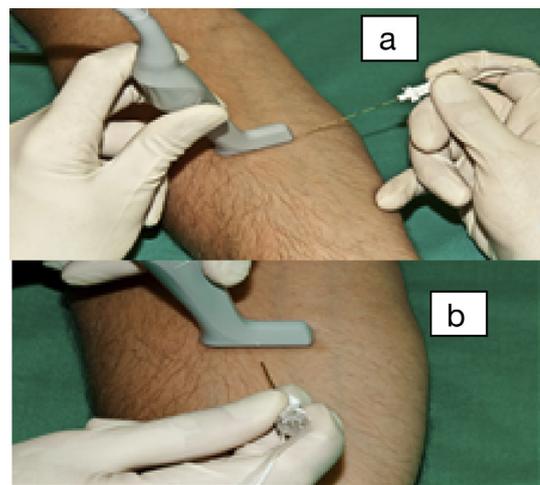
(a) Out-of-plane technique demonstrating needle alignment relatively perpendicular to ultrasound probe. (b) In-plane technique demonstrating needle alignment parallel to ultrasound probe.
